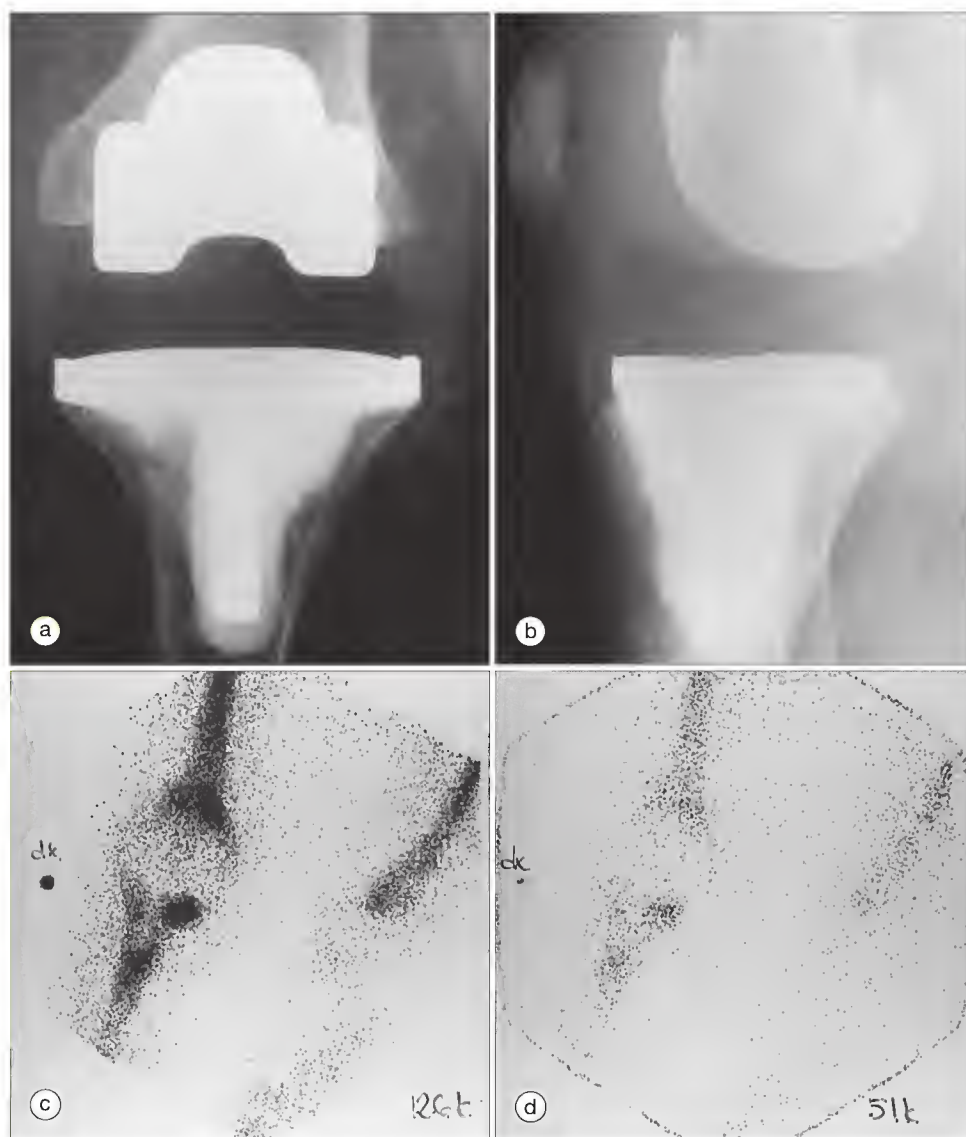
A knee prosthesis 1 year after surgery in a patient with rheumatoid arthritis and severe pain at rest and on weight bearing. (a, b) The radiographs show no abnormalities and no radiolucency. (c) Technetium-99m–nanocolloid scintigraphy shows obvious increased uptake corresponding to the distal femur and proximal medial tibia. (d) The uptake with Indium-111–leukocyte scintigraphy was increased in a similar distribution.
